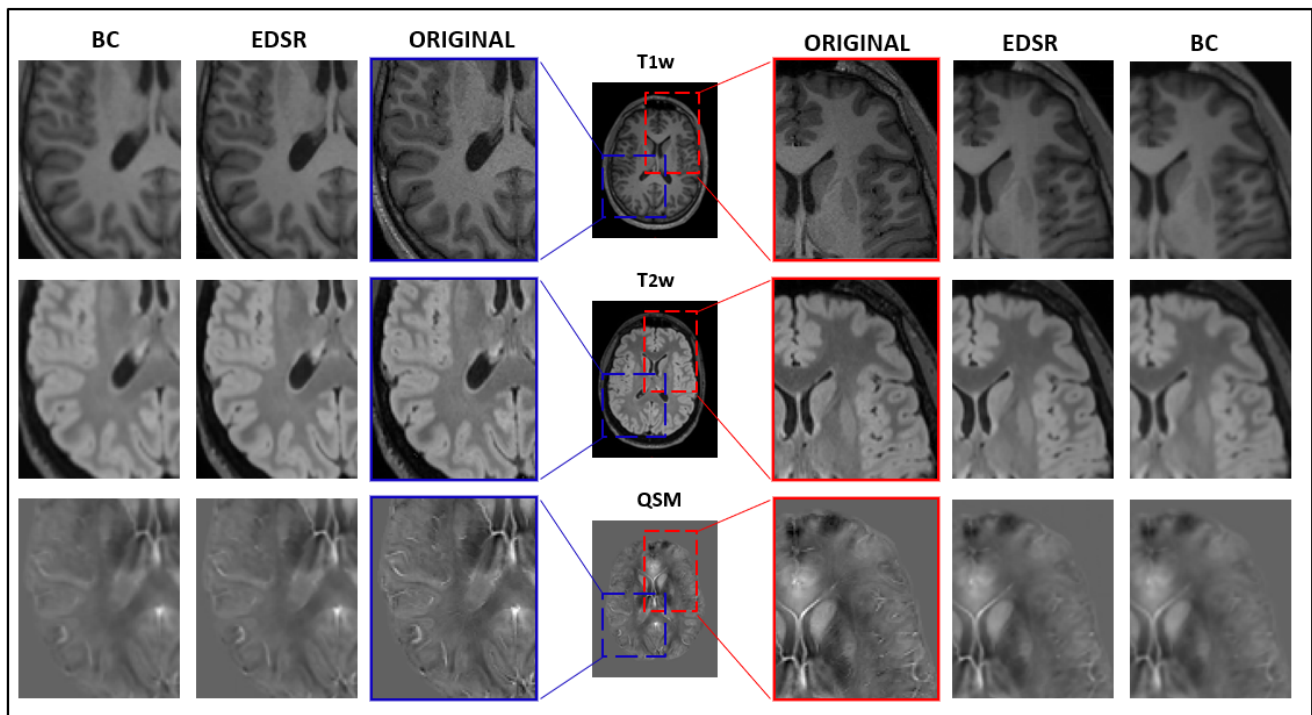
Example of MPRAGE, FLAIR and QSM images of a representative subject (healthy control, M/24 years old) (IRCCS Istituto delle Scienze Neurologiche di Bologna, Functional and Molecular Neuroimaging Unit), comparing the original ones with EDSR and BC reconstructions. From the images, it can be observed that EDSR better reconstructs the original than BC interpolation, restoring high spatial-frequency structures in more detail
